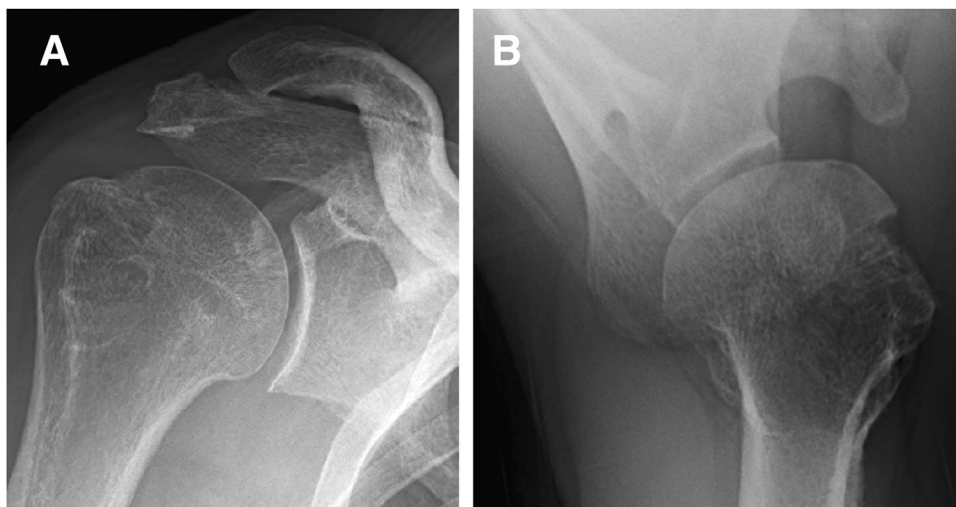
Demonstration of anteroposterior (A) and axillary (B) radiographs of the right shoulder 4 months after osteochondral allograft implantation using the BioHumi technique for treatment of a reverse Hill-Sachs lesion after a locked posterior dislocation.
